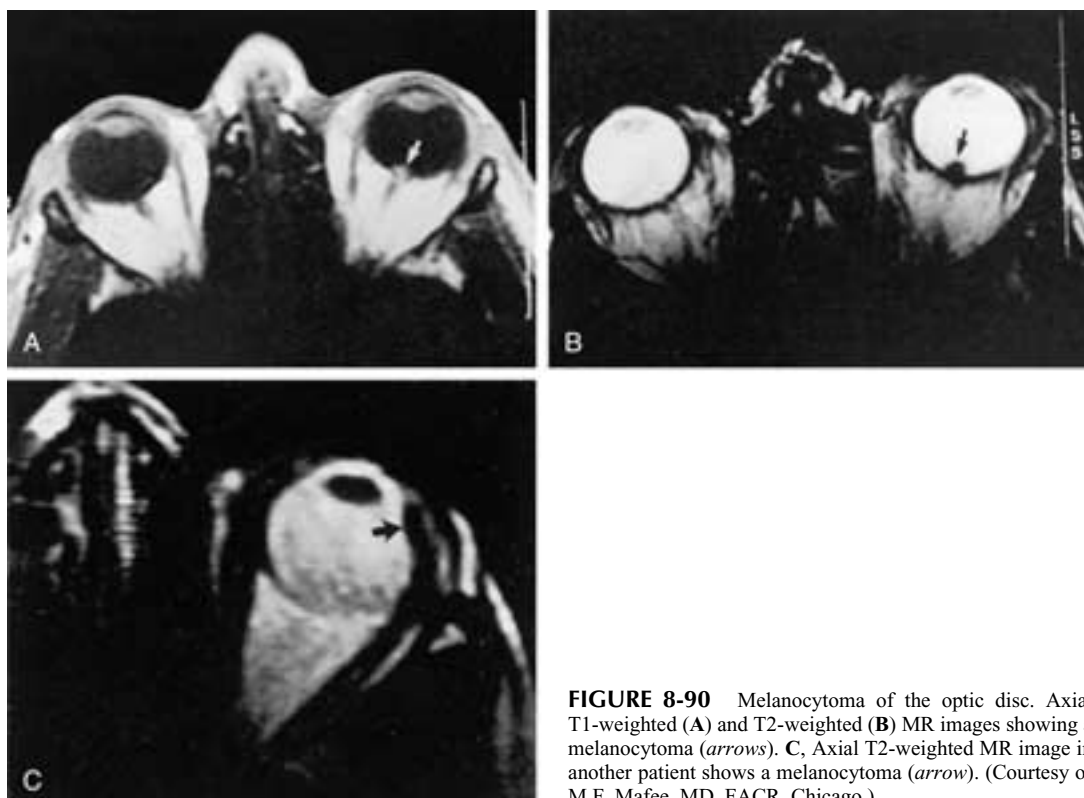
Melanocytoma of the optic disc. Axial T1-weighted (A) and T2-weighted (B) MR images showing a melanocytoma (arrows). C, Axial T2-weighted MR image in another patient shows a melanocytoma (arrow). (Courtesy of M.F. Mafee, MD, FACR, Chicago.)
